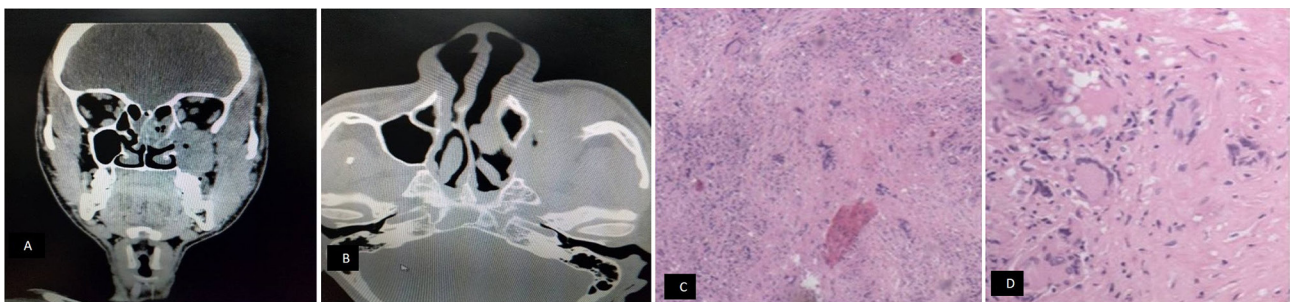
(A, B) Contrast-enhanced CT (CECT) of paranasal sinuses (PNS) showing mass occupying the left maxillary sinus with destruction of all the walls except the medial wall. (C, D) High-power view showing ill-defined granuloma composed of epithelioid cells, Langhans-type giant cells, lymphocytes and plasma cells.
